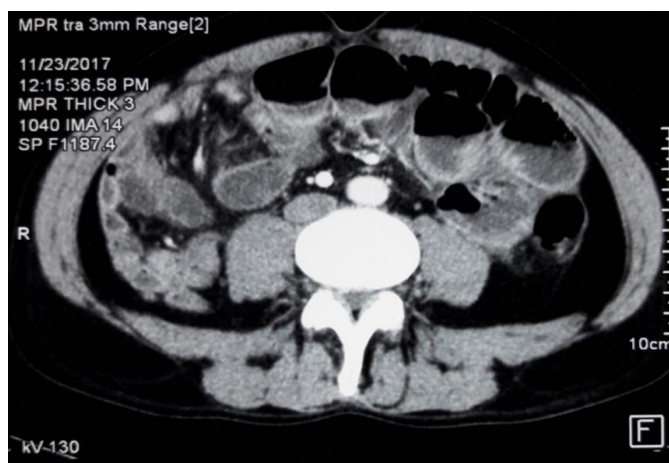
Computerized tomography (CT) scan of the abdomen showing dilated small bowel loops.
